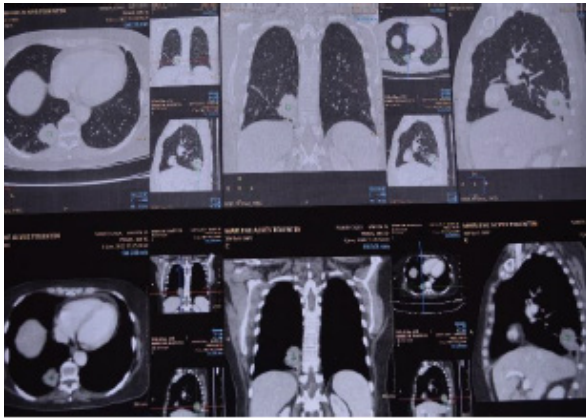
Computed tomography (CT) for staging shows a rounded lung mass with well-defined limits and irregular contours compatible with clinical reports of a primary neoplastic lesion located in the posterior segment of the right lower lobe, subpleural, presenting heterogeneous contrast enhancement and measuring approximately measuring 3.3 x 3.1 cm in the largest axial axes. Absence of pleural effusion. No evidence of mediastinal lymph node enlargement. Bone structures without changes of oncological relevance.
